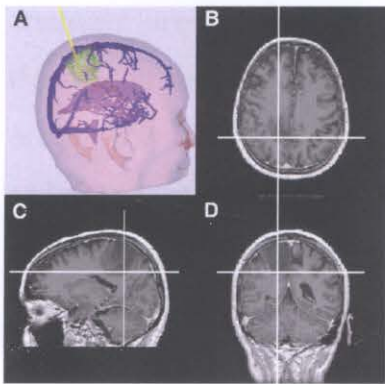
MRI Image used for Cranial Navigation
